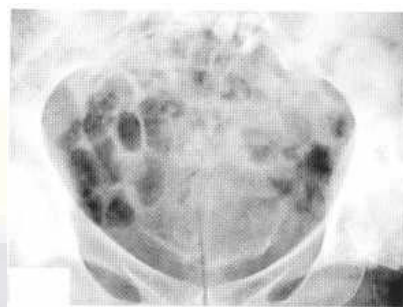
Plain film of the bladder area showing irregular calcification over a bladder carcinoma.
